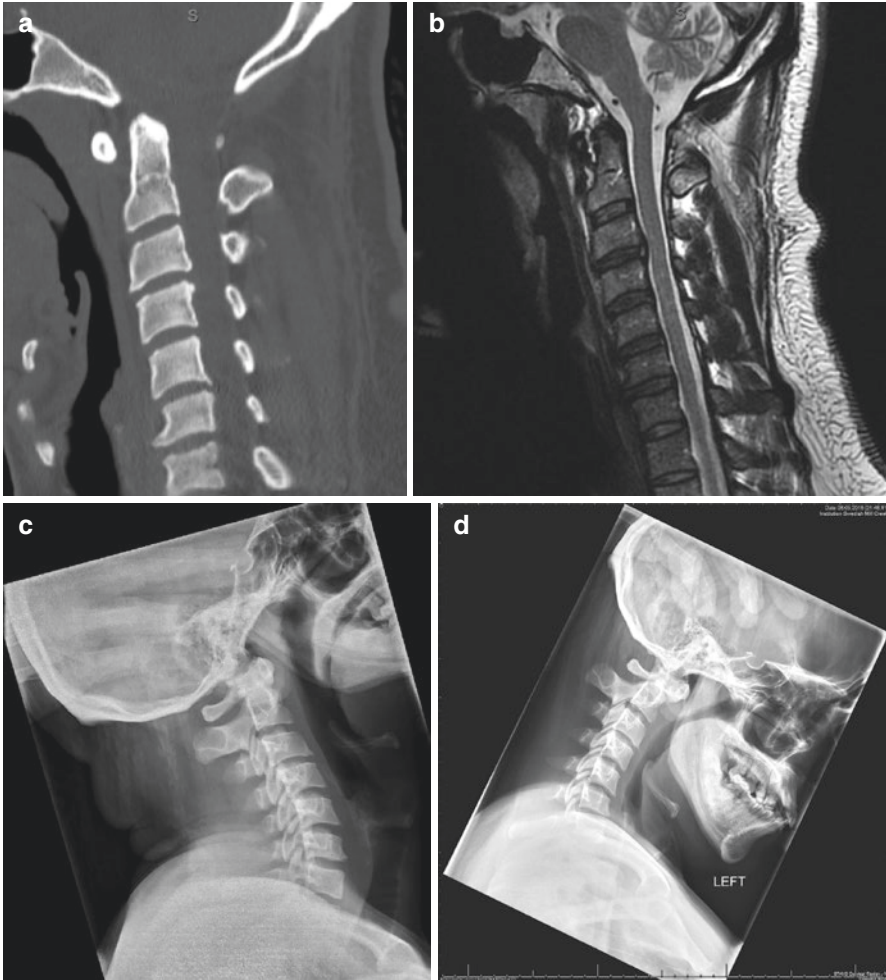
A 36-year-old male presented to the ED with neck pain and positional upper extremity paresthesias. CT (a) and MRI (b) of the cervical spine showed no obvious fracture but an atlanto-dental interval of >2 mm. Flexion and extension plain films (c, d) show blatant translation of the atlas relative to the dens, confirming a C1 Type B injury
